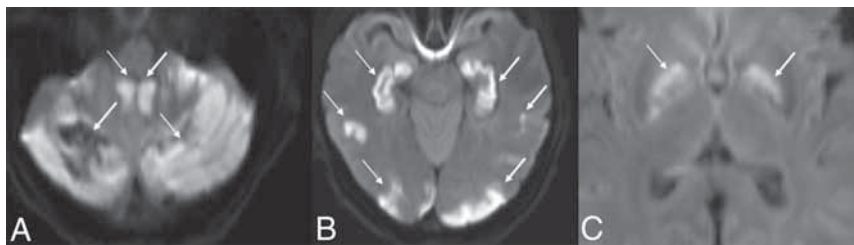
MR DWI from patient 1, thirty hours after presentation, shows diffusion restriction in the cerebellum (white arrows, A), hippocampi and cortex (white arrows, B), and basal ganglia (white arrows, C). The ADC map is not shown.
